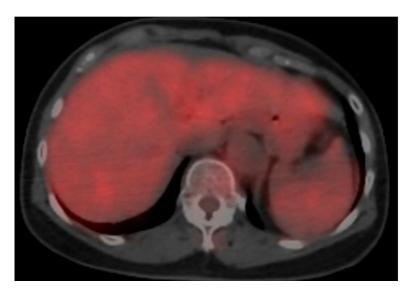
Positron emission tomography/computed tomography (PET / CT) findings. PET / CT showed no avid radiotracer uptake in the liver.
